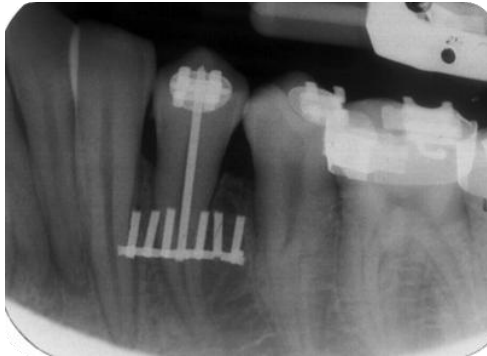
Intraoral periapical radiograph(Parallel cone technique) with the wire guide
